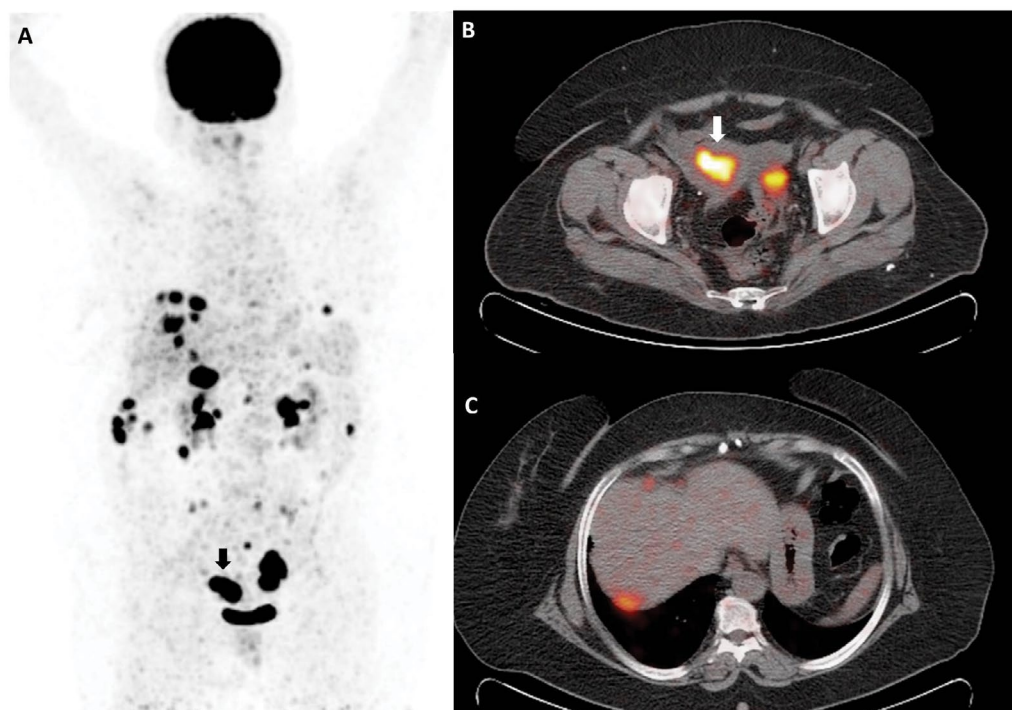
The MIP (A) and fusion (B, C) images of a 61-year-old patient with stage 4B mixed endometrial cancer and a capsular implant in the liver are presented. The PET parameters of the primary tumor of the patient (A, B; arrows) were calculated as follows: SUVmax: 24.4, SUVmean: 8.5, MTV: 17.8 mL, and TLG: 151.3 g. The progression-free survival and overall survival of this patient were 8 months and 16 months, respectively
